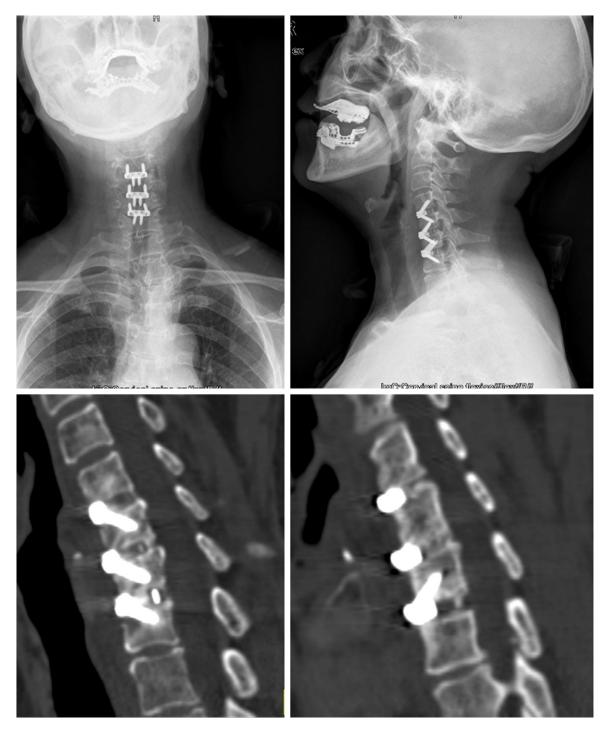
Three months postoperative X-rays and CT scan.
